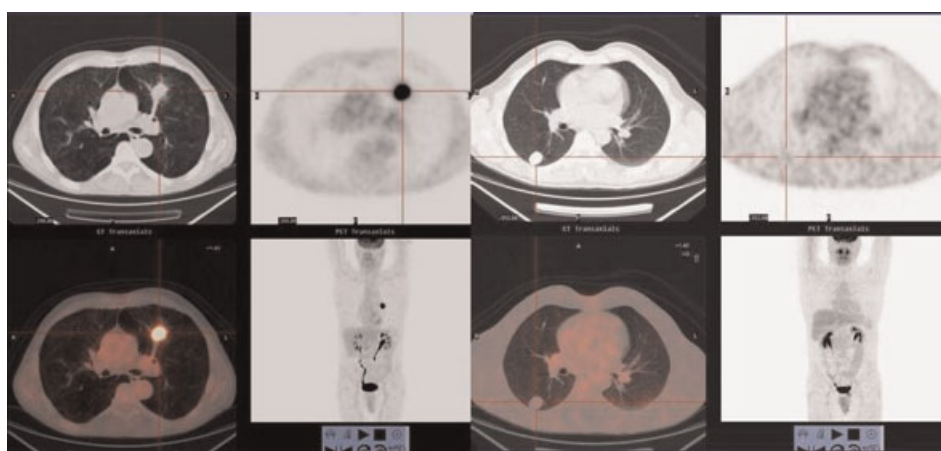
PET-CT. Hypermetabolic pulmonary nodule (malignant) (left). Ametabolic pulmonary nodule (benign) (right).
